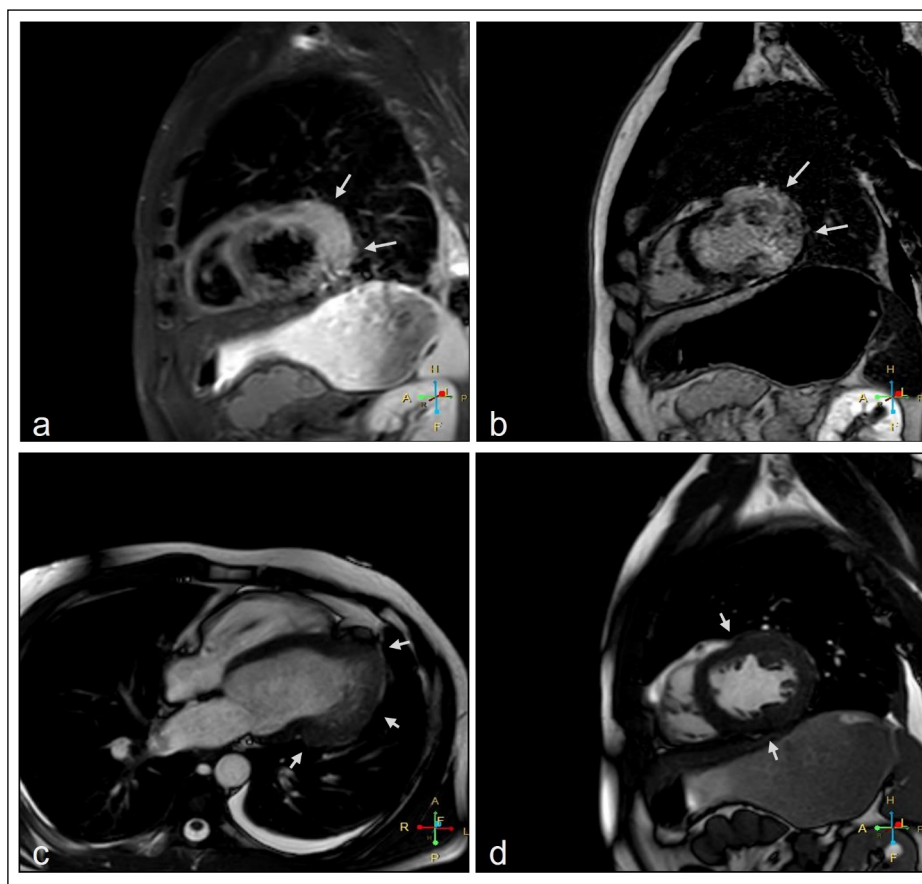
Cardiac magnetic resonance imaging (a) short-axis view shows myocardial edema and (b) late gadolinium enhancement in the left ventricle lateral wall; (c) 4-chamber apical view and (d) short-axis view showing a partial absence of the pericardium and myocardial indentation (arrows).
